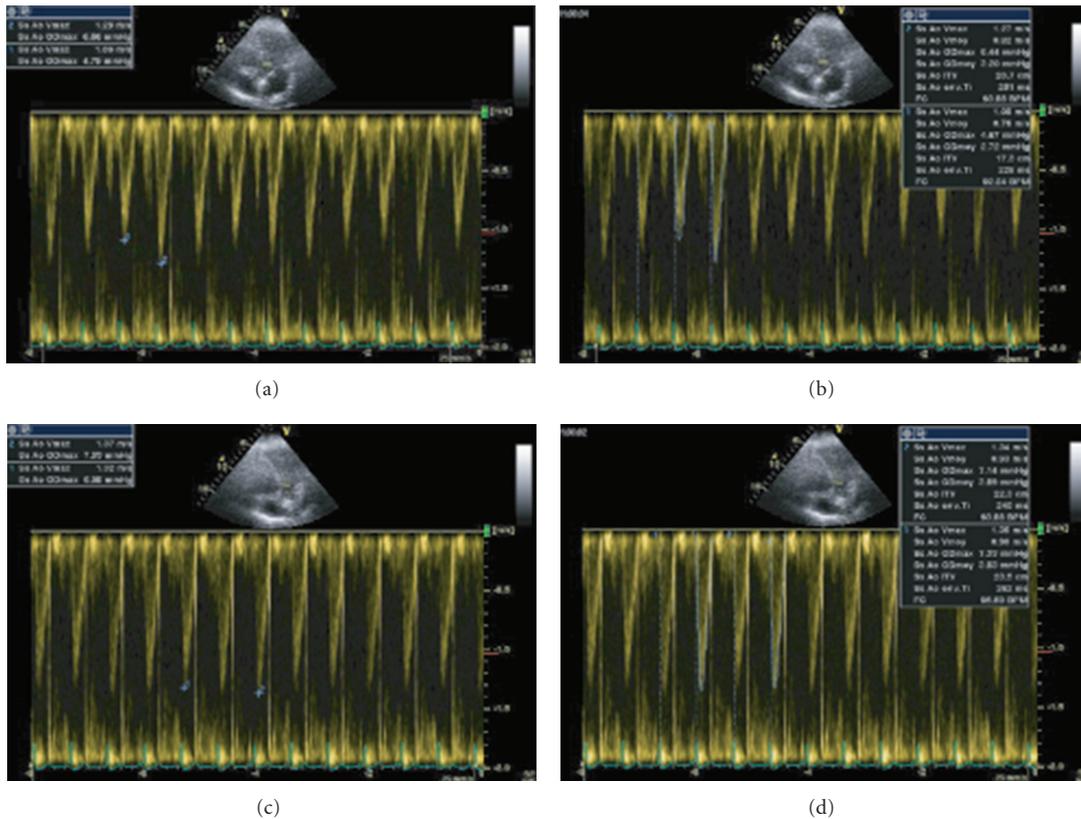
Respiratory variations of maximal velocity (V_{max}) (a and c) and VTI (b and d) of aortic blood flow recorded with a pulsed Doppler transthoracic echocardiography in a mechanically ventilated patient (a and c). Presence of significant respiratory variations of V_{max} ($V_{max} - V_{min}/[V_{max} + V_{min}/2]$; $1.29 - 1.09/1.19 = 17\%$) and VTI ($VTI_{max} - VTI_{min}/[VTI_{max} + VTI_{min}/2]$; $20.7 - 17.3/19 = 18\%$). (b and d) Same patient after volume expansion, regression of the respiratory variations: V_{max} ($1.37 - 1.32/1.34 = 4\%$), VTI ($23.5 - 22.3/22.9 = 5\%$). Reproduced with permission from Levitov et al. "Critical care Ultrasonography" Mc Graw Hill 2009.
